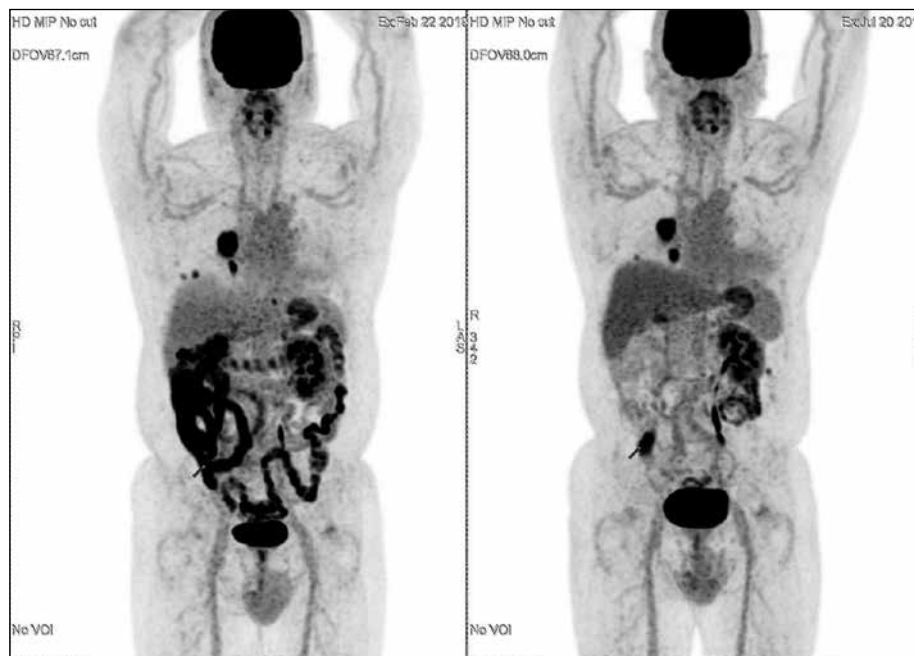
A case of renal cell carcinoma of the right kidney with lung metastases in a 64-year-old man was referred for follow-up FDG PET/CT. MIP image of the FDG PET-CT study on metformin (a) showing intense small and large bowel activity of grade 4 by the visual score scale. MIP image of the second FDG PET-CT study after metformin discontinuation showed focal uptake in the caecum of SUVmax 6.7, now discernible with reduced large bowel uptake of grade 1. The patient was advised to undergo colonoscopy for evaluation.
